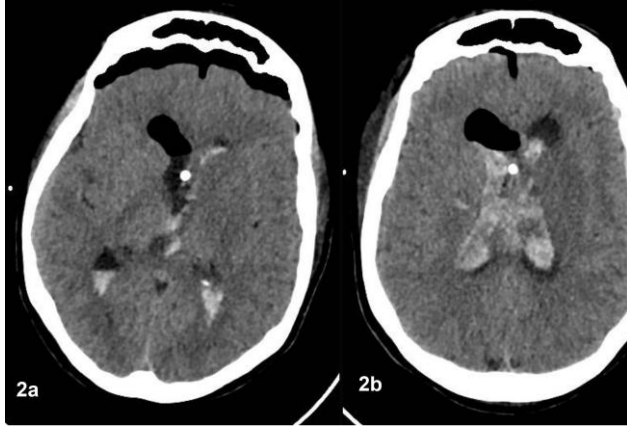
Postoperative CT scans. (A) Small amount of intraventricular blood, consistent with expected findings in the immediate postoperative period. (B) Repeat CT showing an increased volume of intraventricular hemorrhage and worsening signs of intracranial hypertension.
